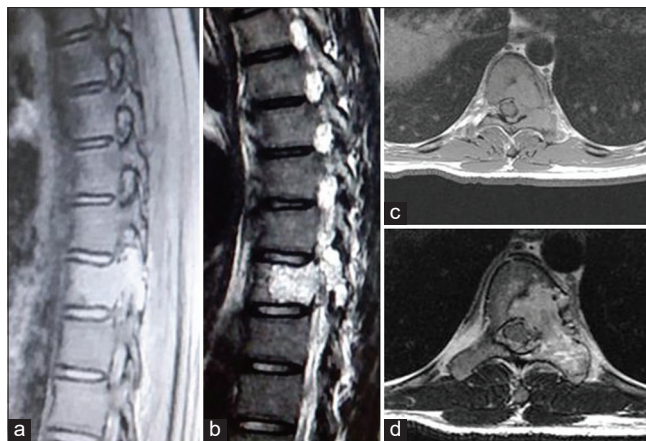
MRI of the spine. (a and b) T1- and T2-weighted sagittal image revealed a heterogeneous bony cystic mass with internal septation and fluid-fluid levels at the T9 vertebra. (c and d) Axial T1- and T2-weighted images showing large, expansile spinal lesion with multiple fluid levels typical for an aneurysmal bone cyst and cord compression.
